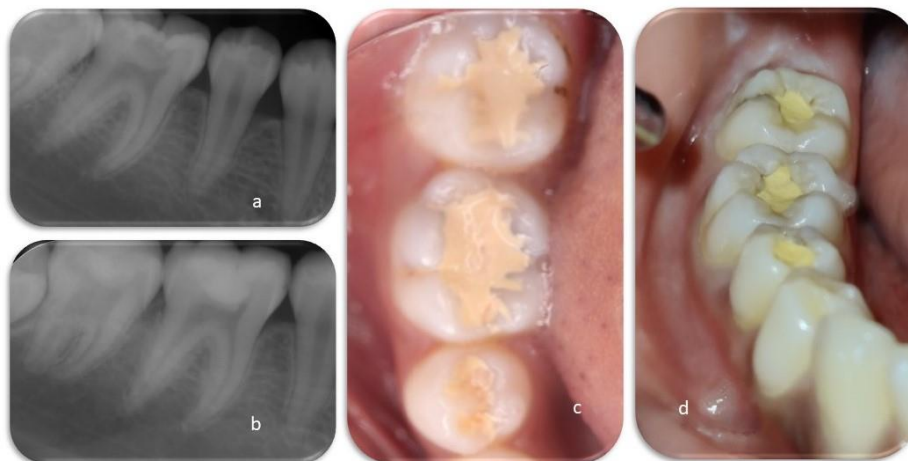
Biodentine treatment of teeth 45,46,47, all with severe deep caries (a,c). A 21-month follow-up showed radiographically healthy teeth (b). Clinically, all fillings were still in place and performing well (d). Tooth 45 was not included in the study.
